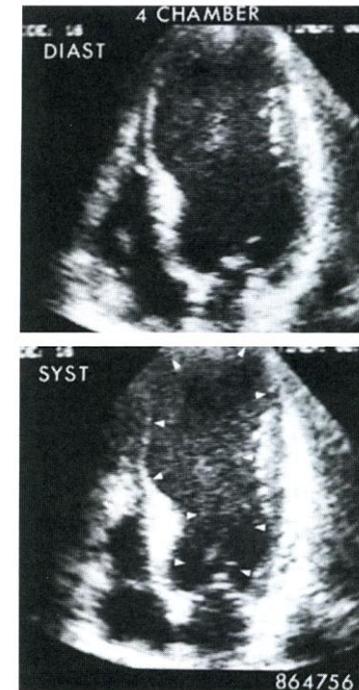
Apical four-chamber view in a patient with a scarred, dilated, aneurysmal apex and distal interventricular septum. The proximal half of the septum has normal thickness and contracts normally with systole.
